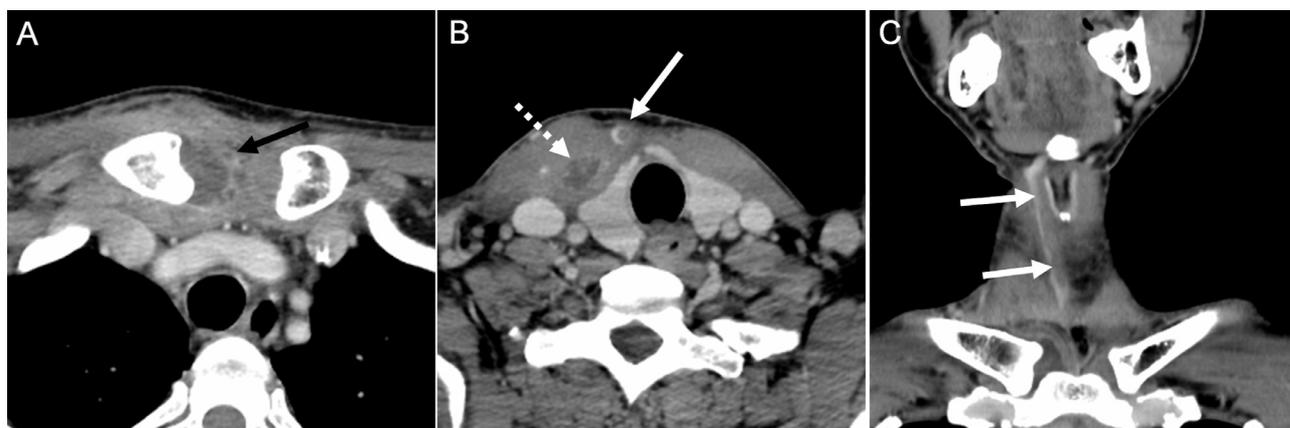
A 56-year-old who presents with right neck swelling. A contrast-enhanced CT examination was performed with reconstructions in the axial (A,B) and coronal (C) planes which demonstrates a rim enhancing fluid collection consistent with an abscess associated with the right sternoclavicular joint consistent with septic arthritis (A, arrow). There is abscess tracking superiorly along the right sternocleidomastoid muscle (B, dashed arrow). In addition there is a tubular filling defect within the right anterior jugular vein (B,C white arrows). This represents another case of septic thrombophlebitis but of the anterior rather than internal jugular venous system.
